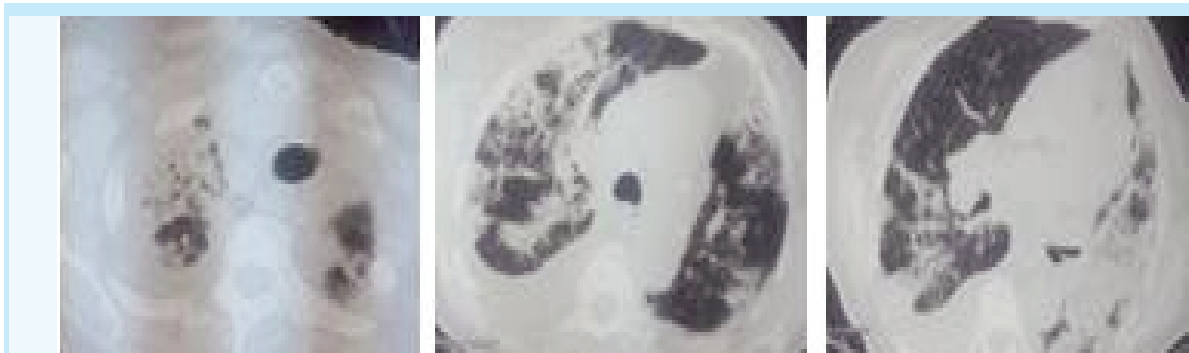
Pulmonary computed tomography showing interstitial diffuse infiltration
